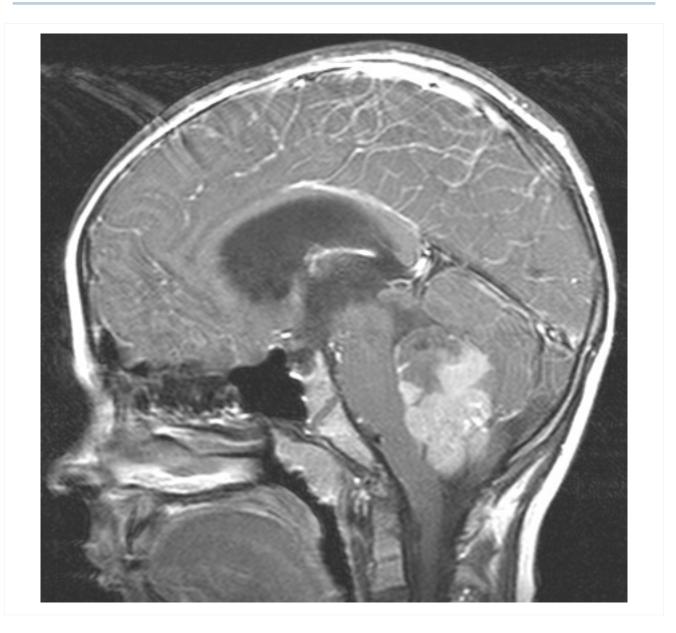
Medulloblastoma: sagittal view MRI showing an avidly enhancing solid and cystic lesion filling the fourth ventricle; obstructive hydrocephalus present
